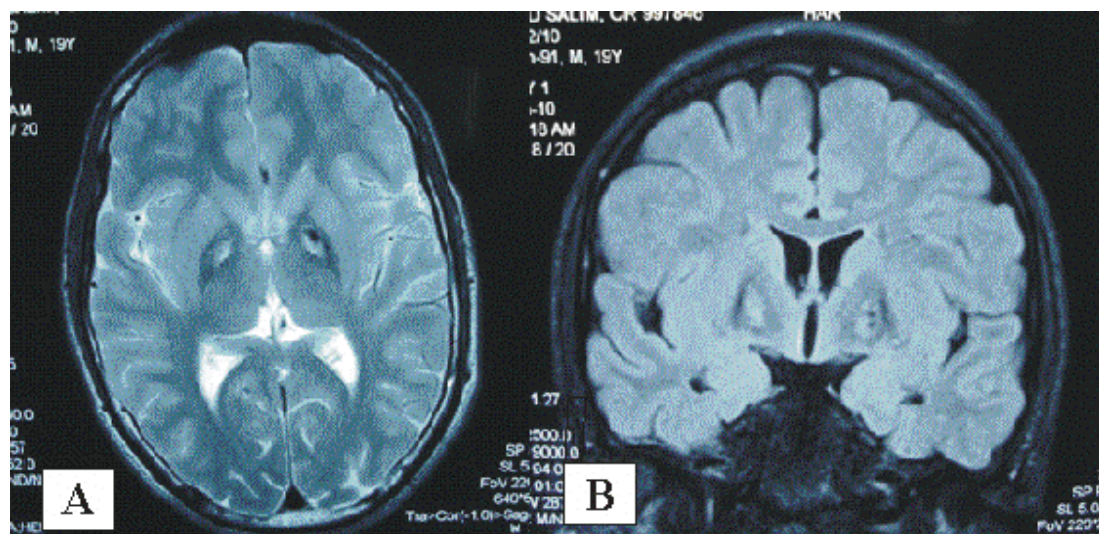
(A) Axial T2W imaging and (B) Coronal T2 FLAIR imaging showing hypointensity with central area of hyperintensity in both globus pallidi (Eye-of-the-tiger sign).
